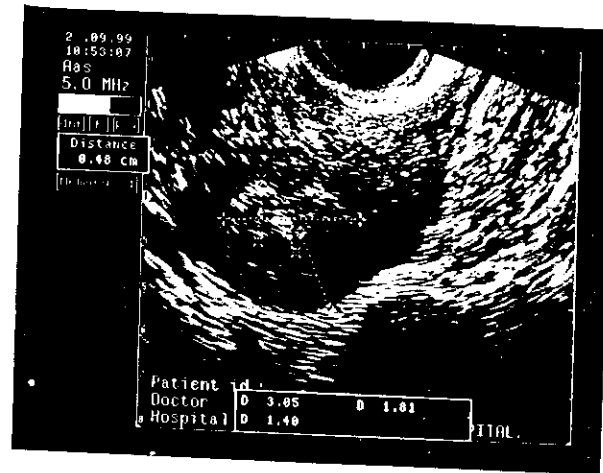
Shows sonographic picture of endometrial carcinoma.
